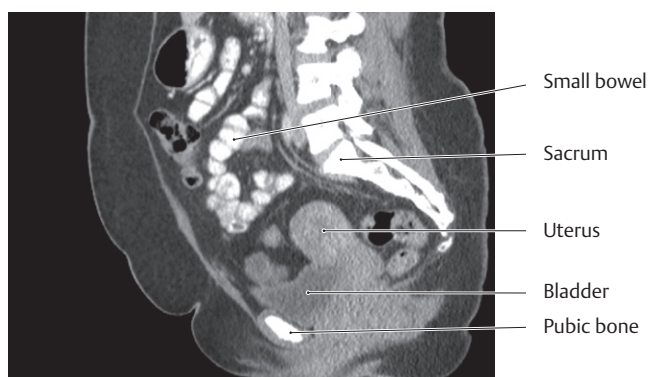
CT of the female pelvis
